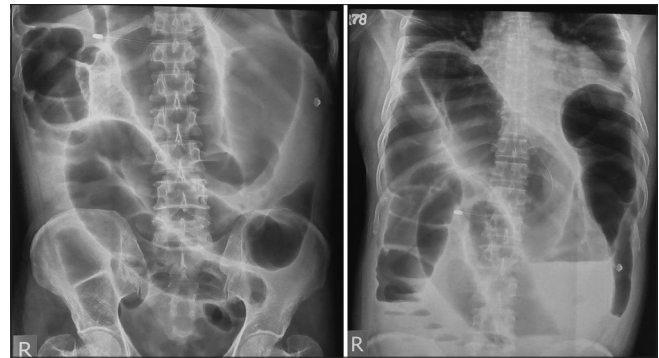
Abdominal antero-posterior supine and erect radiographs shows dilated large bowel loops with few air fluid levels, suggestive of large bowel obstruction
